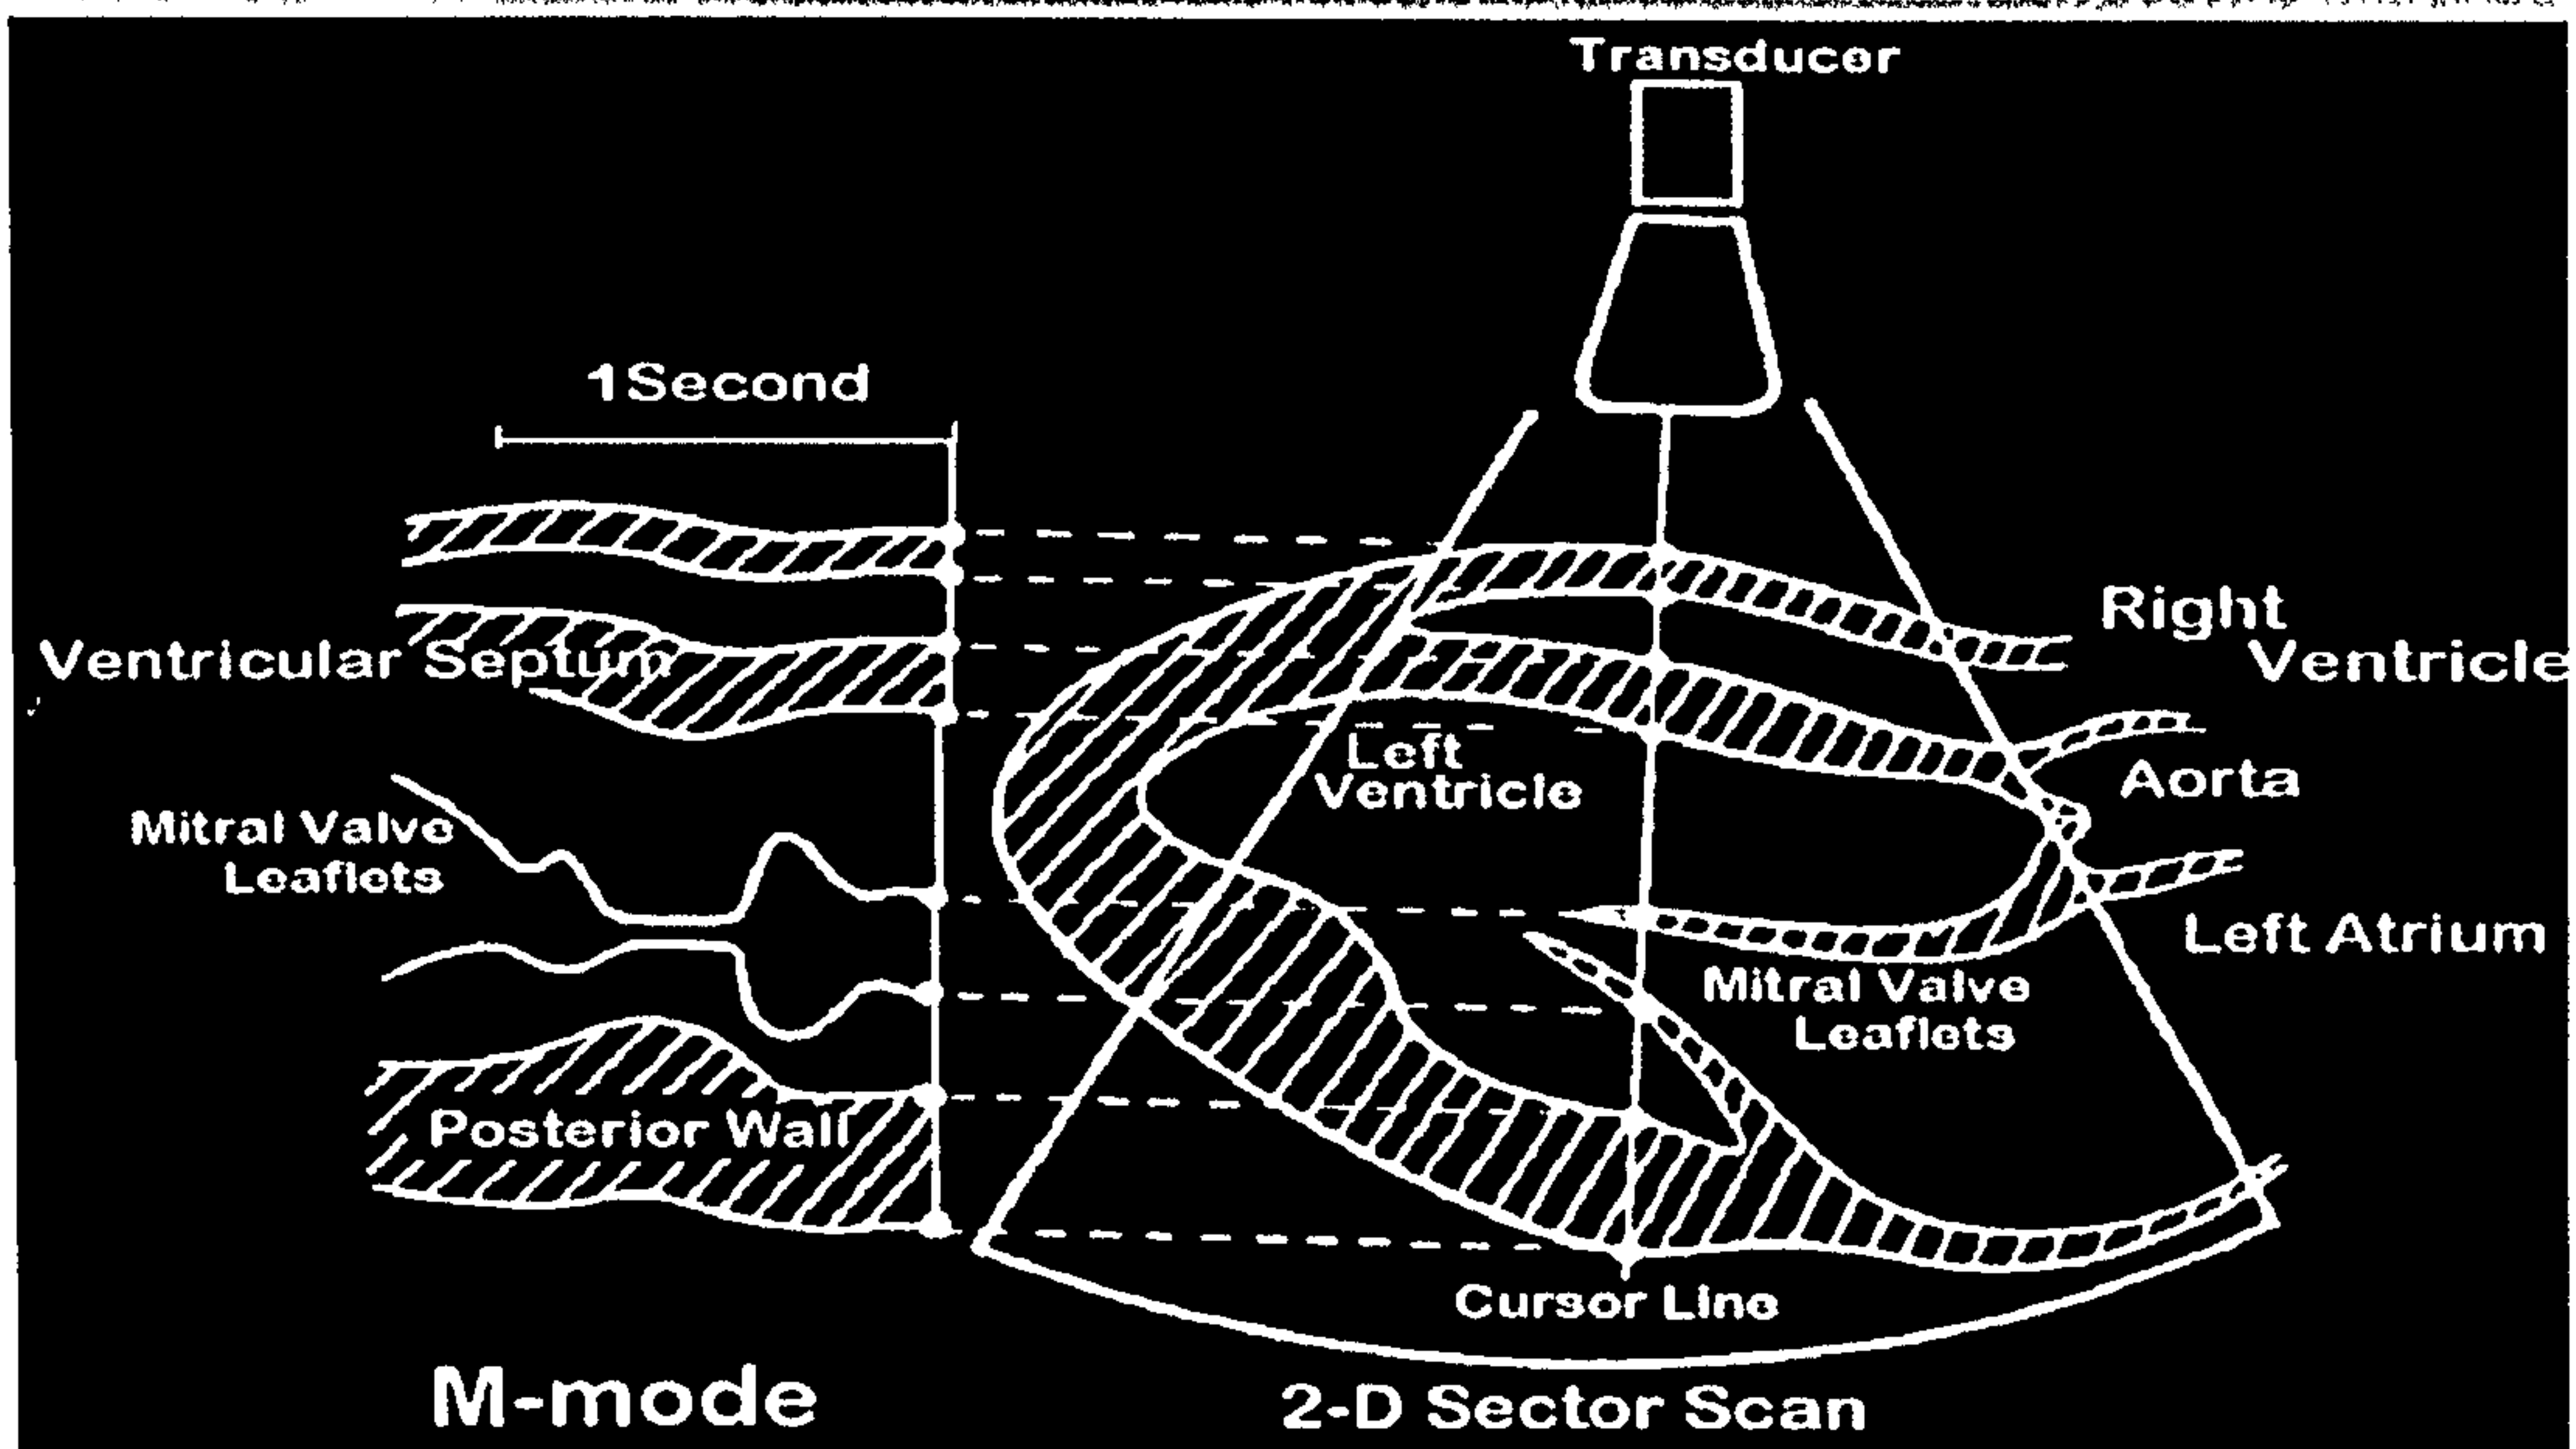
Image of the left ventricle as assessed through ultrasound.
